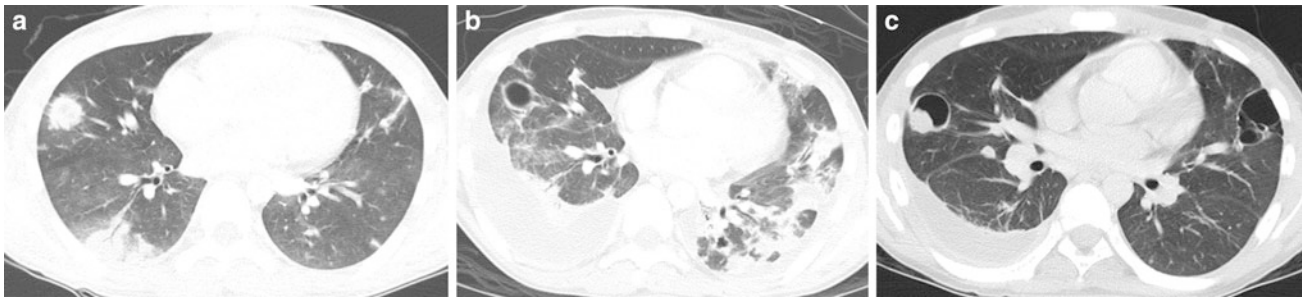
Invasive aspergillosis. An axial chest CT image (a) in a febrile neutropenic 12-year old with acute lymphoblastic leukemia undergoing induction chemotherapy shows multiple pulmonary nodules with a ground-glass “halo” in the right lung. An axial chest CT image
